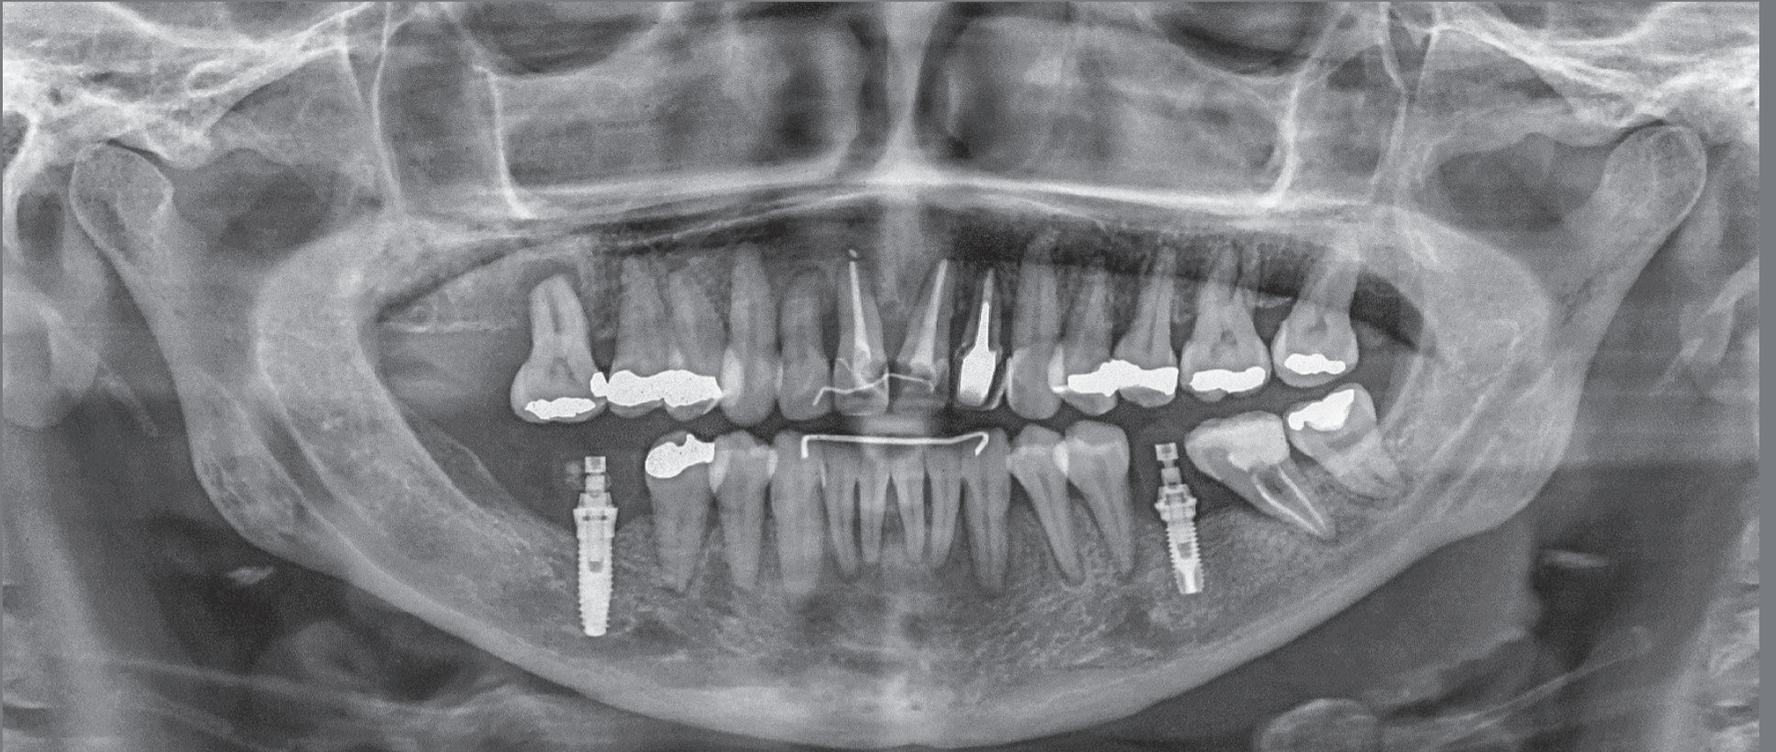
Panoramic radiograph at the end of treatment.
